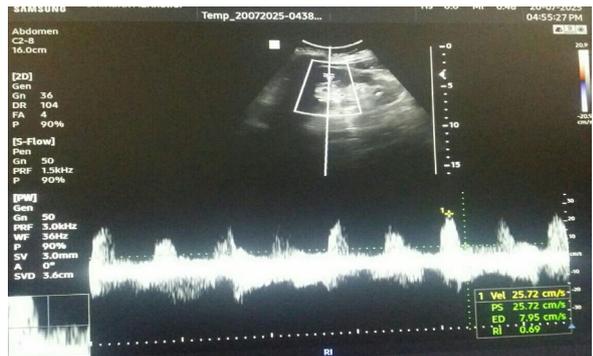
Spectral doppler of interlobar artery with measuring of resistive index.
